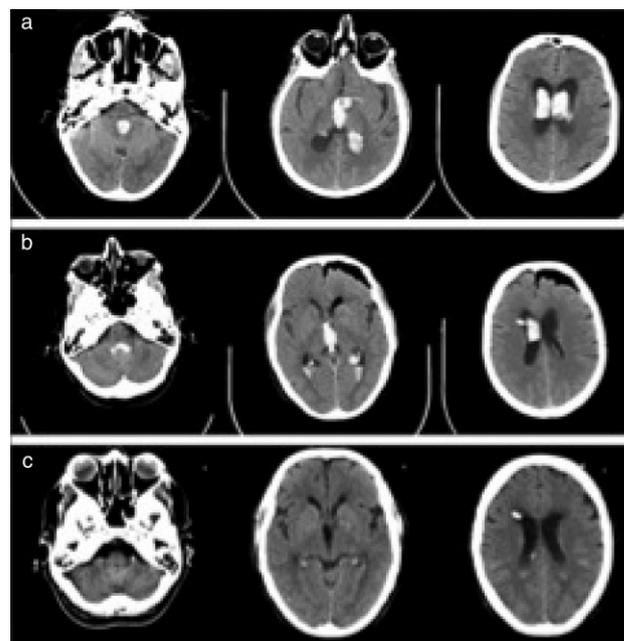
Representative CT images through the 4th, 3rd, and lateral ventricles of a patient treated with the Apollo System. Preoperative (a), 12-hours post-aspiration (b), and 12-hour post t-PA (c) images are shown.
